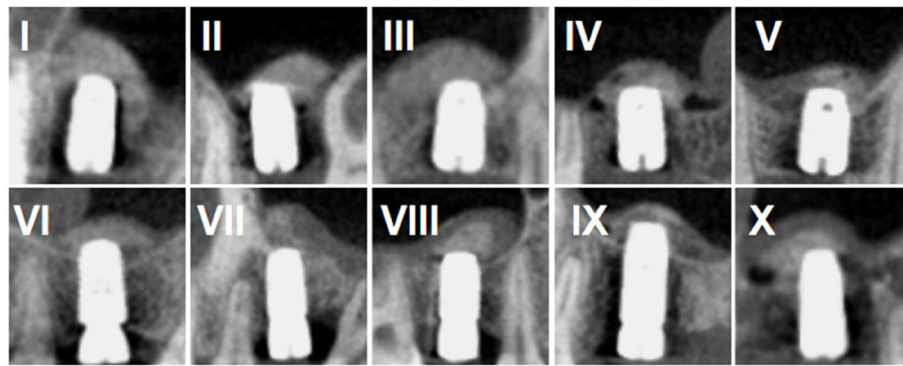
Postoperative CBCT image of each case
